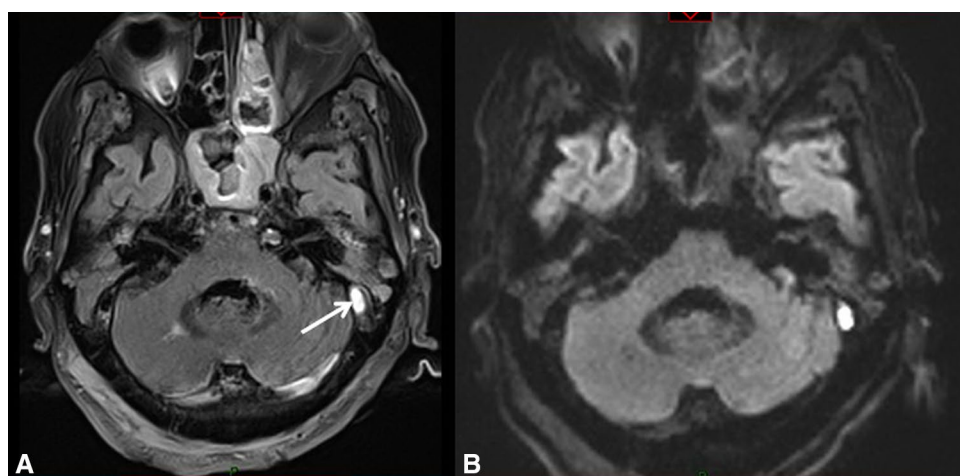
Brain MRI with FLAIR (a) and DWI (b) sequences. Demonstration of an acute clot within the left transverse sinus (white arrow) with restriction of water diffusivity on DWI
